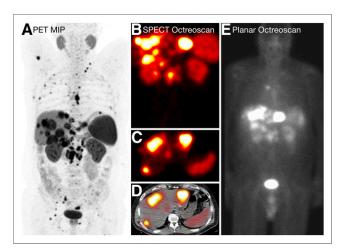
Example of agreement. All 3 imaging studies were read by all readers as having Krenning score of 5. SSTR PET demonstrates more lesions (A), particularly in bones, than SPECT (B–D) and planar imaging (E). Extent of disease was graded as 5 by all readers (i.e., at least 1 lesion larger than 5 cm and more than 5 lesions). MIP = maximum-intensity projection.
